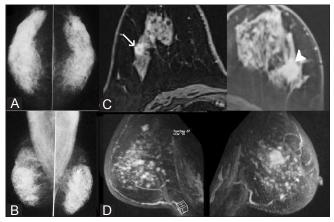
(A-E): A 55-year-old female with proven malignancy in the left breast. X-ray mammography CC (A) and MLO (B) views show dense breasts and an obscured density in the upper outer quadrant of the left breast (arrow). Axial contrast-enhanced high-resolution inter-VIEWS (C) and sagittal oblique 1-minute subtraction MIP image (D) show a spiculated mass in the left breast (arrowhead, proven malignancy) and a subcentimeter size spiculated mass in the right breast (arrow). Subsequent MRI-guided biopsy from the MRI-detected lesion in the right breast revealed IDC. This was a true-positive MRI imaging finding
